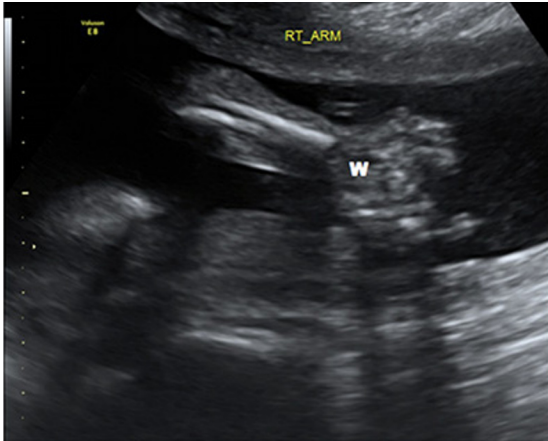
Fetal sonogram shows normal size of right forearm muscles; radius and ulna are demonstrated. W, fetal wrist.
